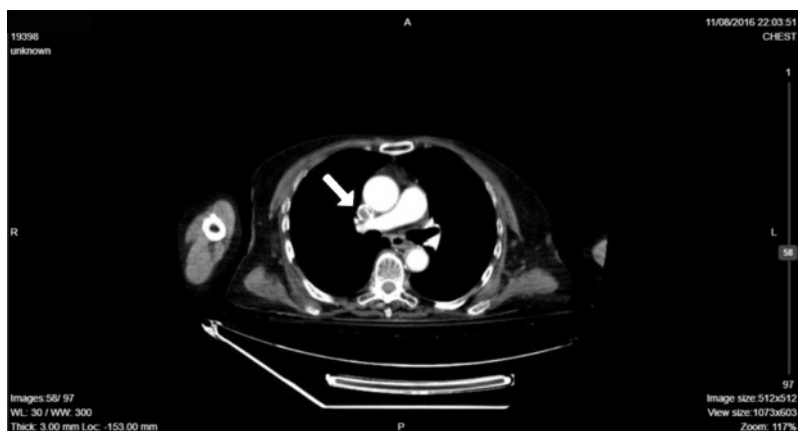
Another CT image of superior vena cava thrombosis.
